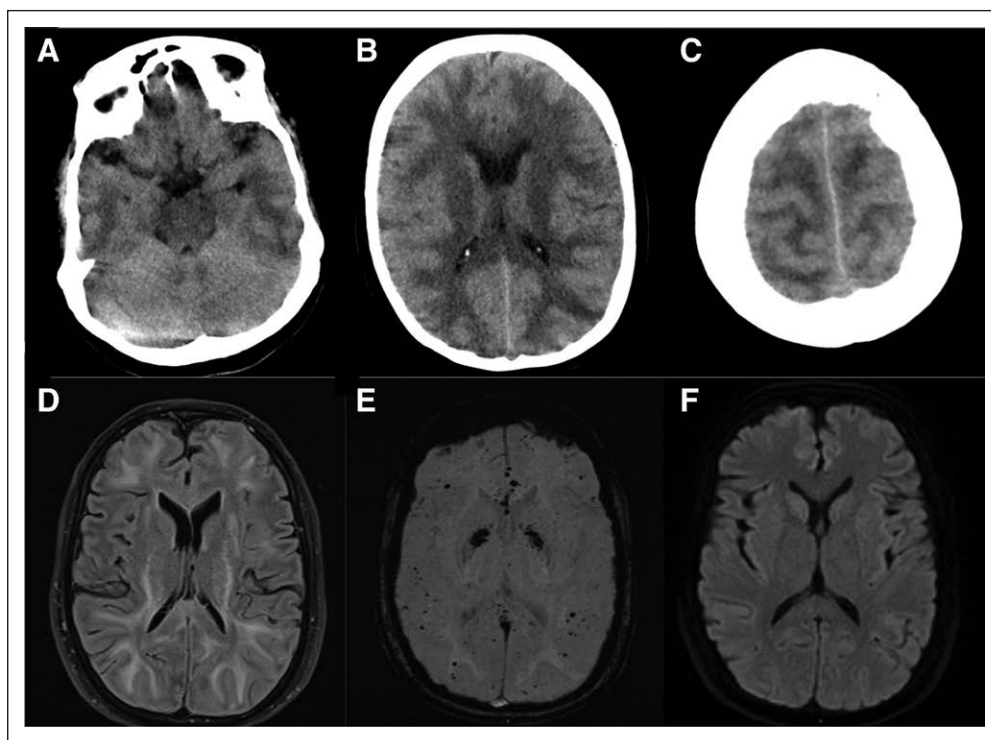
CT and MRI of the brain. The CT scans (A–C) showed white matter brain edema with compressed convexity sulci. The MRI scans (D–F) showed increased white matter intensity on flair images (D), microhemorrhages with involvement of basal ganglia on SWI (E), and no signal changes on diffusion-weighted imaging (DWI) (F). The findings resembled acute hemorrhagic leukoencephalitis. SWI = susceptibility-weighted imaging.
